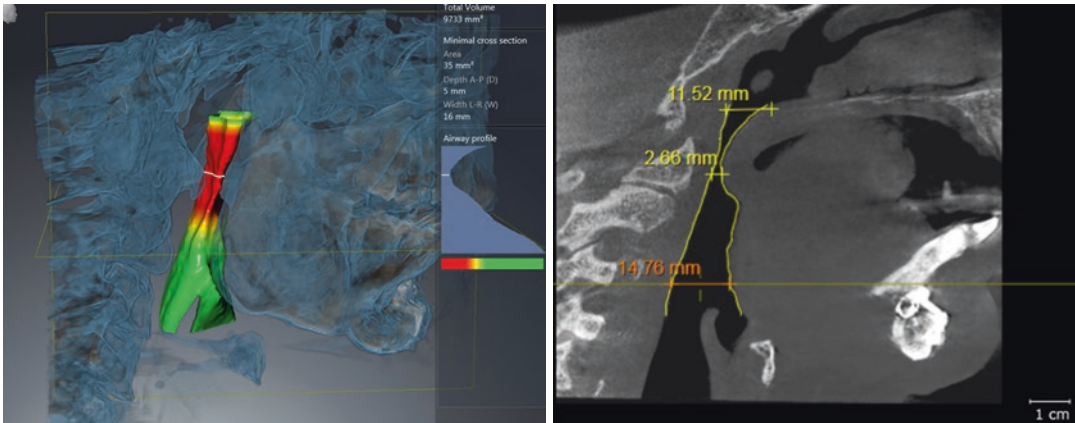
Radiographic analysis of the airway passage depicting the narrow airway resulting in obstructive sleep apnoea in patients with temporomandibular joint ankylosis
